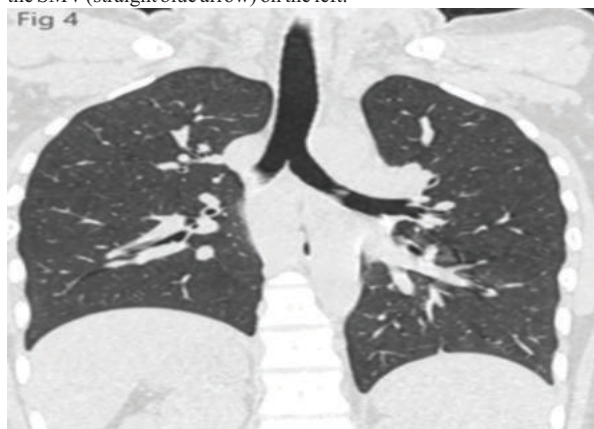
Chest computed tomography plain study showing bilateral bilobed lungs, with main bronchi coursing inferiorly to the pulmonary artery.
